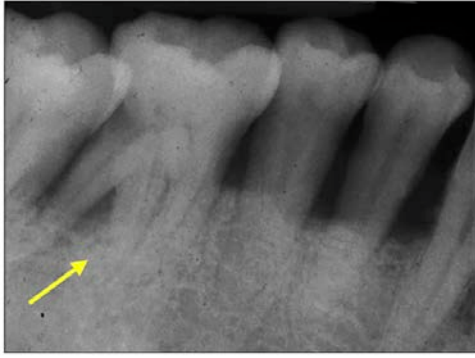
Periapical radiograph of supernumerary tooth root #30.
